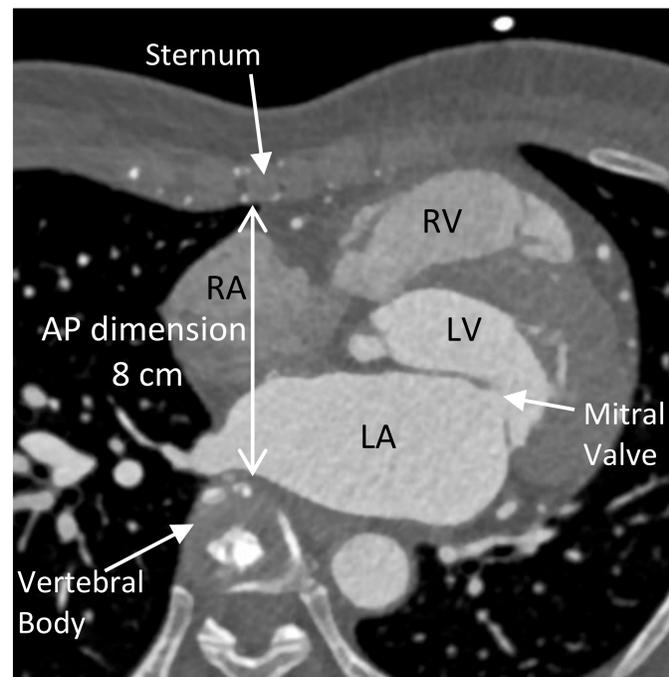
The level of antero-posterior distance was measured at the level of the mitral valve in CT scans as shown.
